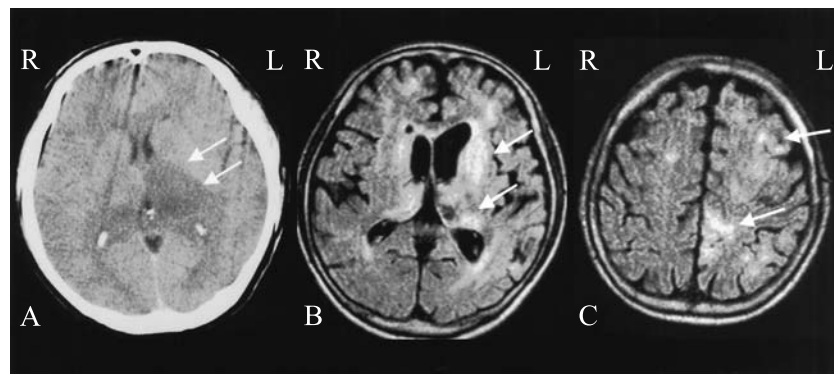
CT and MRIs of Patient 6 with Japanese encephalitis.
